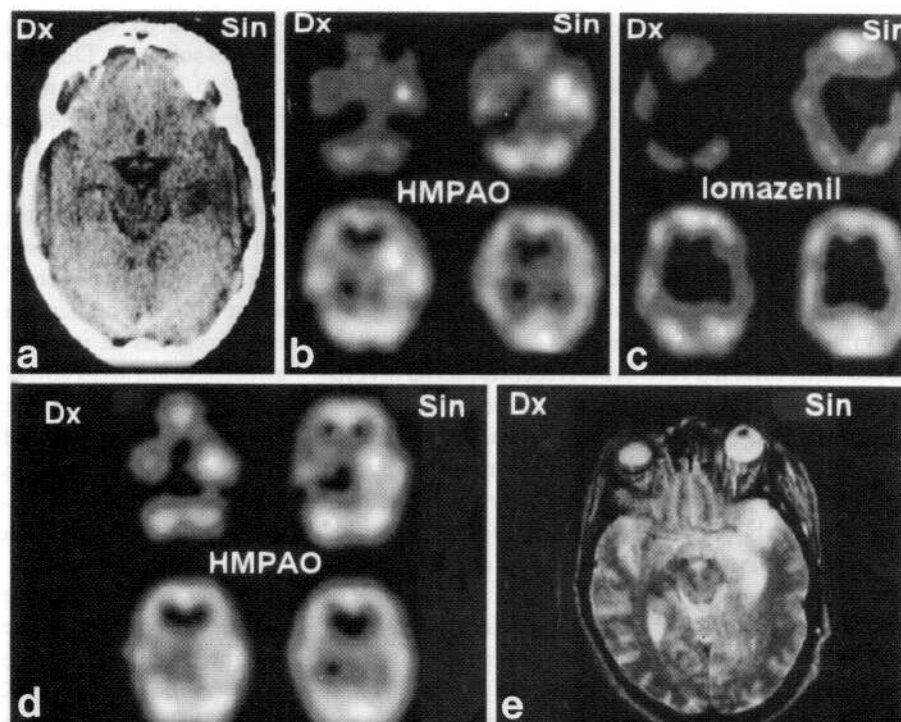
Patient 1. (A) Left temporal hypodensity on CT on day of admission. (B) Hyperfixation of HMPAO in the corresponding region the day after admission. There is a 21% side-to-side difference in the temporal areas. The patient had periodical lateralized complexes on EEG and a few seizures. (C) [¹²³I]iomazenil SPECT on day 8 after admission. Hypofixation of the tracer can be seen on the left as an indicator of neuronal loss. (D) Follow-up ^{99m}Tc-HMPAO SPECT on day 16 after hospitalization. Note the continuing hyperfixation of ^{99m}Tc-HMPAO in the left temporal lobe. Periodic complexes were not seen at this time and the patient no longer had seizures. (E) 1.0 T T2 weighted MRI on day 6 showing hyperintense signal on the left temporal lobe, mainly on the mesial aspect. Note, that the most intense hyperfixation of ^{99m}Tc-HMPAO is also located in the mesial temporal lobe.
